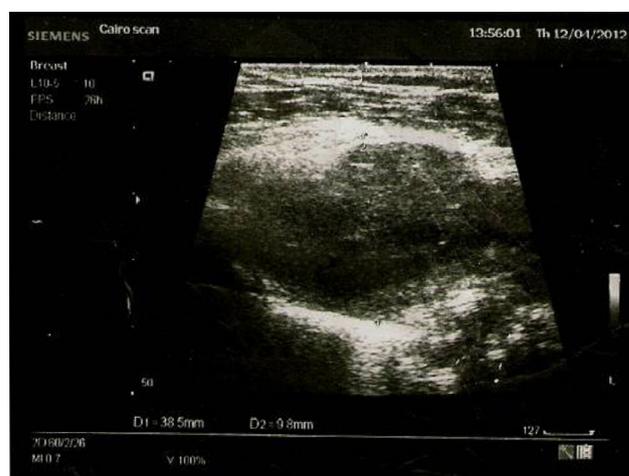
Ultrasound images showing mass lesions affecting the pleura in addition to minimal effusion.
